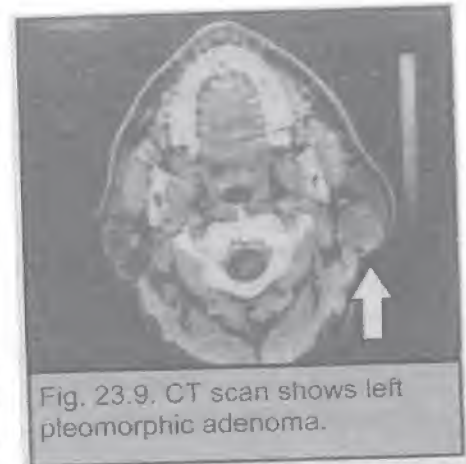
CT scan shows left pleomorphic adenoma.
